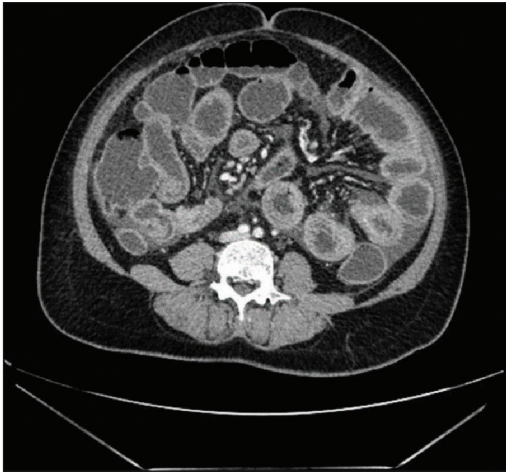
Contrast-enhanced computed tomography abdomen showing jejunal and ileal wall thickening with small mesenteric nodes and ascites
